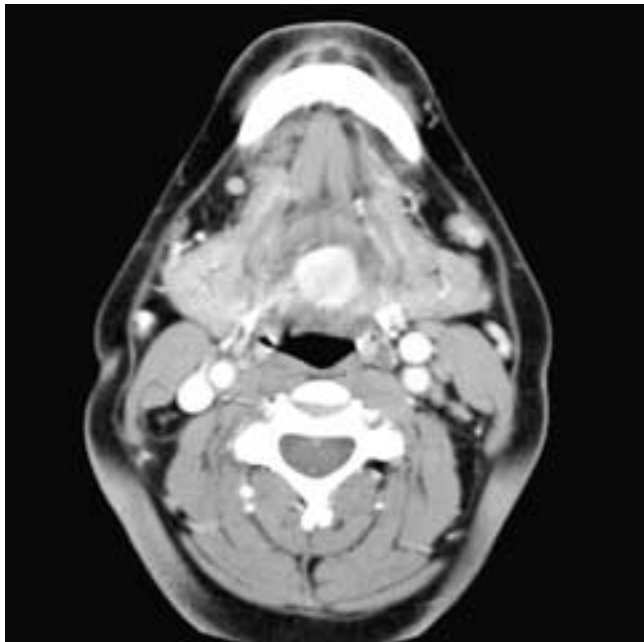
Axial contrast-enhanced CT scan shows an enhancing midline mass in the caudal posterior tongue. This was lingual thyroid tissue.
